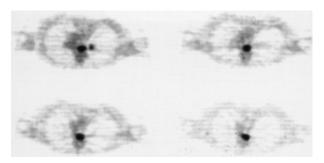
Panels from FDG-PET scan of patient, showing multiple foci of increased uptake in the mediastinum. The patient's CT scan of the chest was entirely normal.
